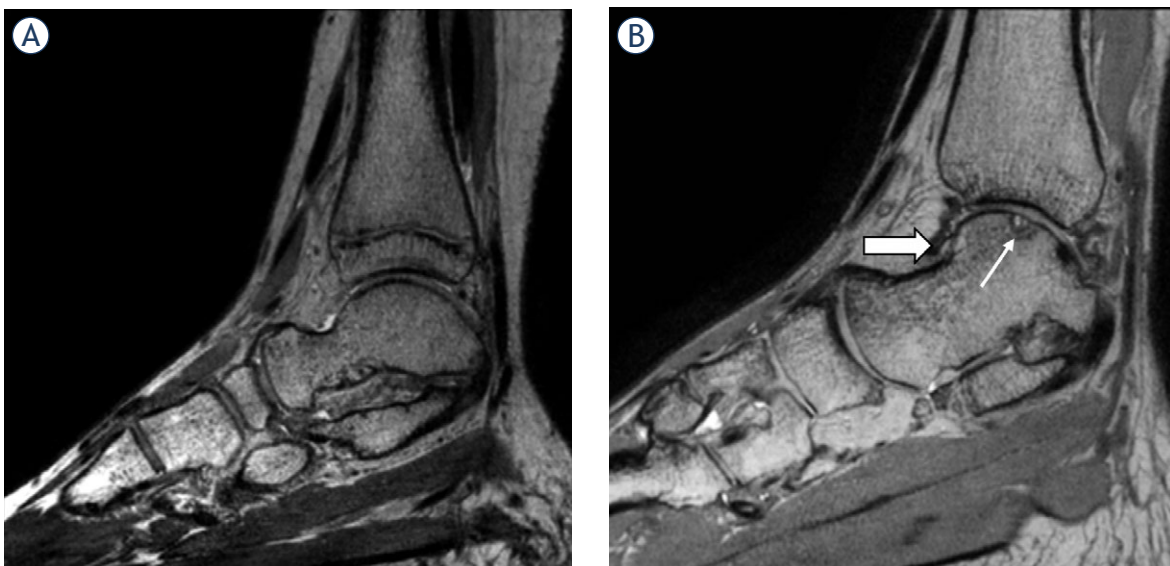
PD weighted MRI of ankles in sagittal plane. Image (A) shows an ankle with no signs of haemophilic arthropathy in an 11-years old boy, while image (B) shows a severely affected ankle in a 17-years old boy. The thin arrow marks a talar osteochondral defect, while the thick arrow marks synovial hypertrophy with hemosiderin deposition.
